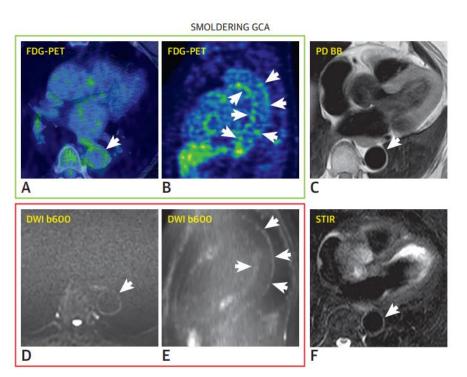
Patient in ongoing treatment without systemic signs and symptoms of GCA. Persistent slight pathological FDG-PET/CT, A. Axial FDG-PET/CT, B. Sagittal FDG-PET/CT; MRI imaging with very little affectation; C. Arterial wall thickness is not increased, D. Axial, E. Sagittal reconstruction, F. No significant vessel wall hyperintensity. Ironi G. et al. (2018) ⁽¹⁸⁾.
